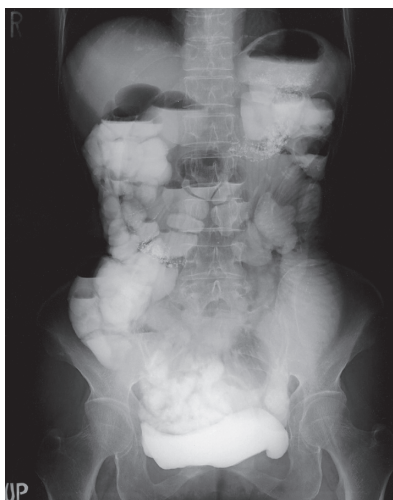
Thoracoabdominal x-ray. There was no abnormality in the chest. Abdominal x-ray revealed extension of the small intestine and air-fluid level. Contrast agent for irri-goscopy was observed in the large intestine.
